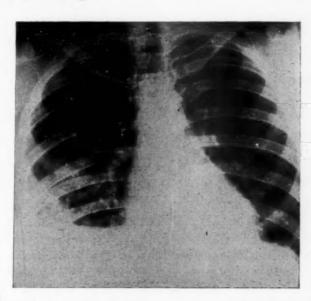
Postoperative chest roentgenogram showing cardiac shadow normal in size and configuration.
